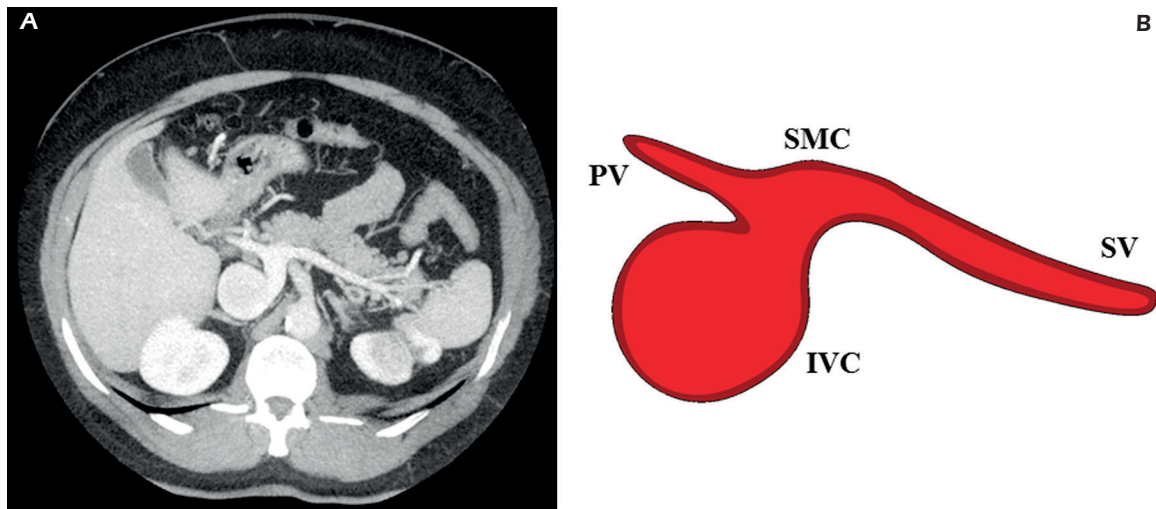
Congenital extrahepatic portosystemic shunts – type 2. A, Contrast-enhanced CT on portal venous phase and axial MIP reconstructions show the presence of a congenital shunt connecting the splenic vein and the splenomesenteric confluence to the inferior vena cava. The liver is perfused with portal blood in the presence of a partial shunt. The portal vein is hypoplastic. B, SV: splenic vein; SMC: splenomesenteric confluence; IVC: inferior vena cava; PV: portal vein.
